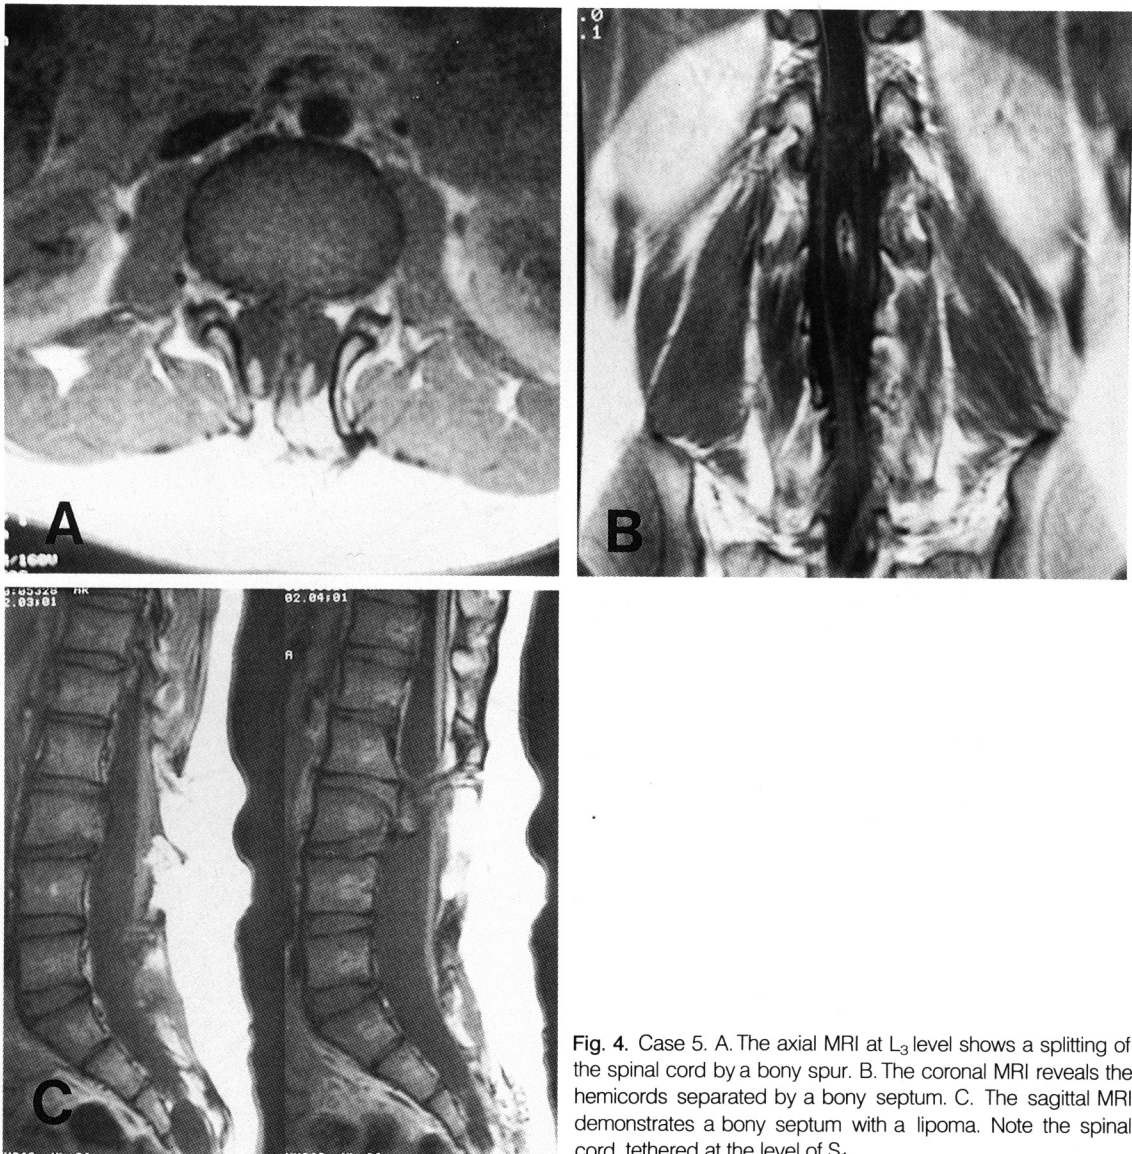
Case 5. A. The axial MRI at L₃ level shows a splitting of the spinal cord by a bony spur. B. The coronal MRI reveals the hemicords separated by a bony septum. C. The sagittal MRI demonstrates a bony septum with a lipoma. Note the spinal cord tethered at the level of S₁.
